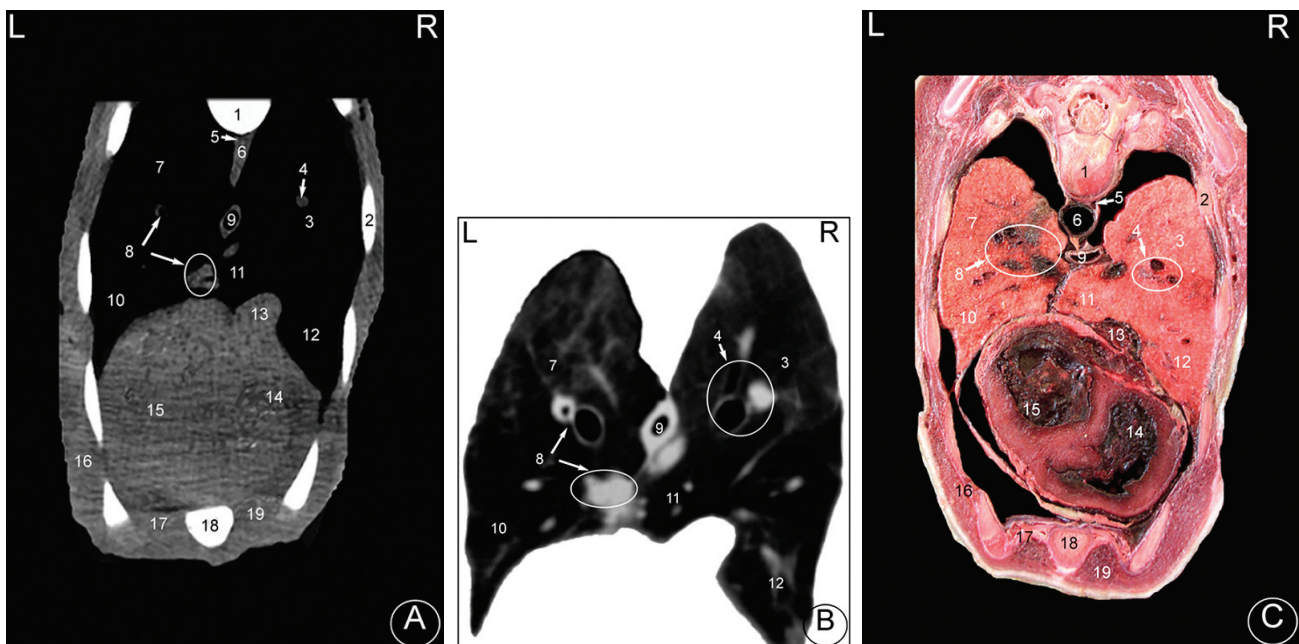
Transverse images at the level of the tracheal carina. (A) CT-soft tissue window image, (B) CT-lung window image and (C) Anatomical cross-section. L: Left; R: Right.
